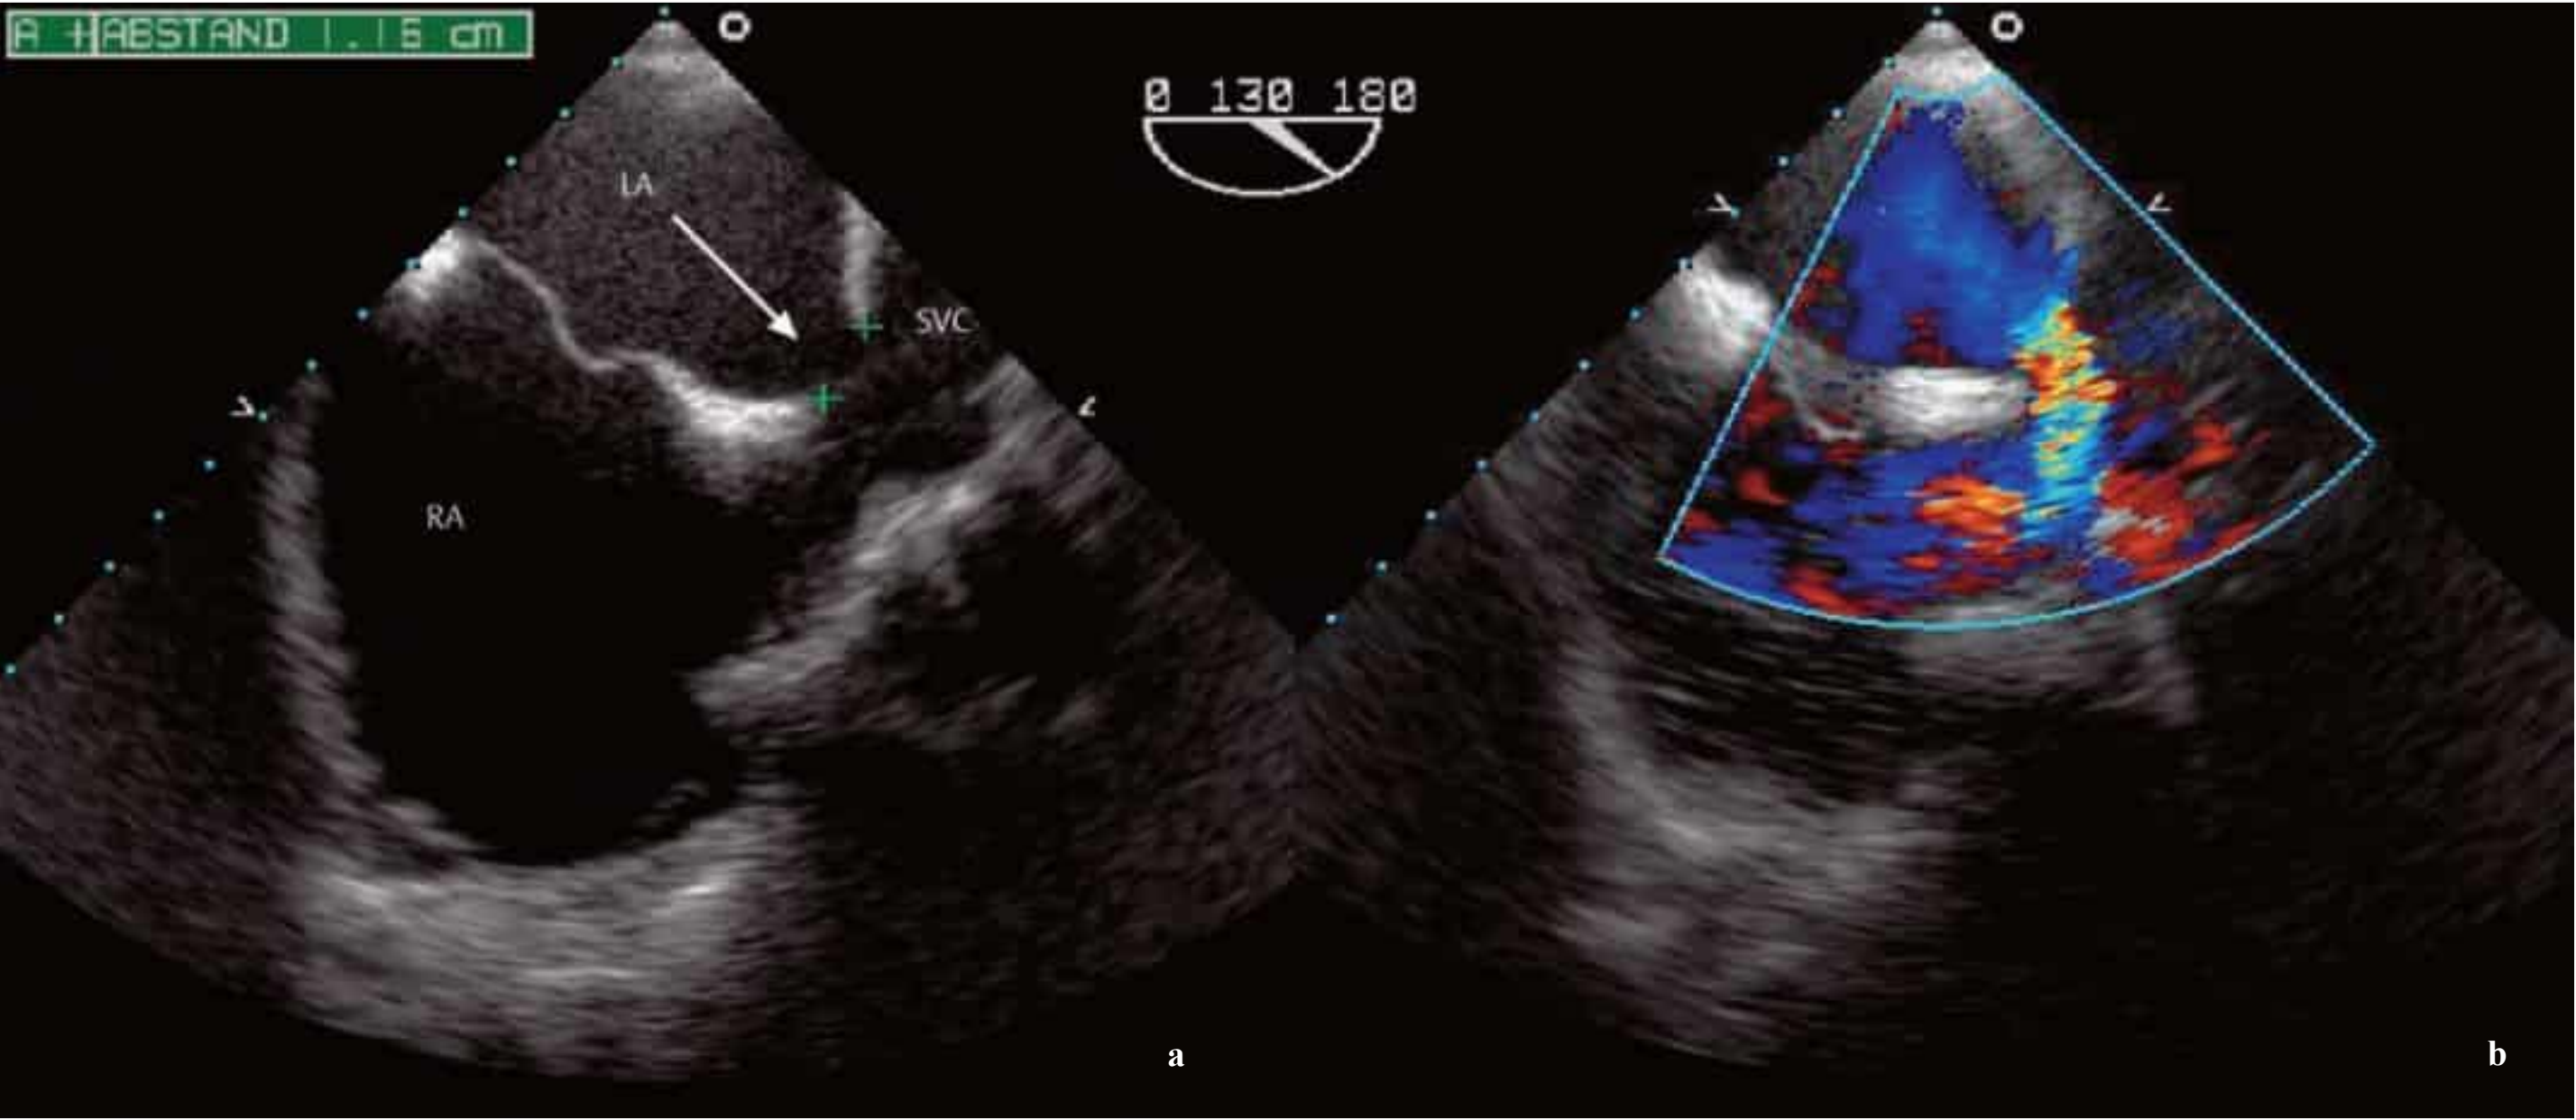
a, b Sinus venosus atrial septal defect documented by transesophageal echocardiography.
